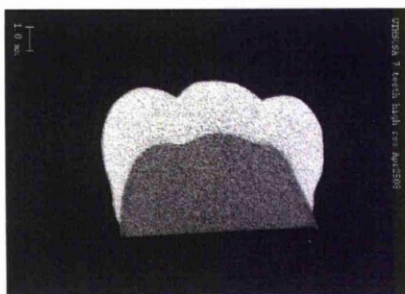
Example of an image produced by Micro CT.
